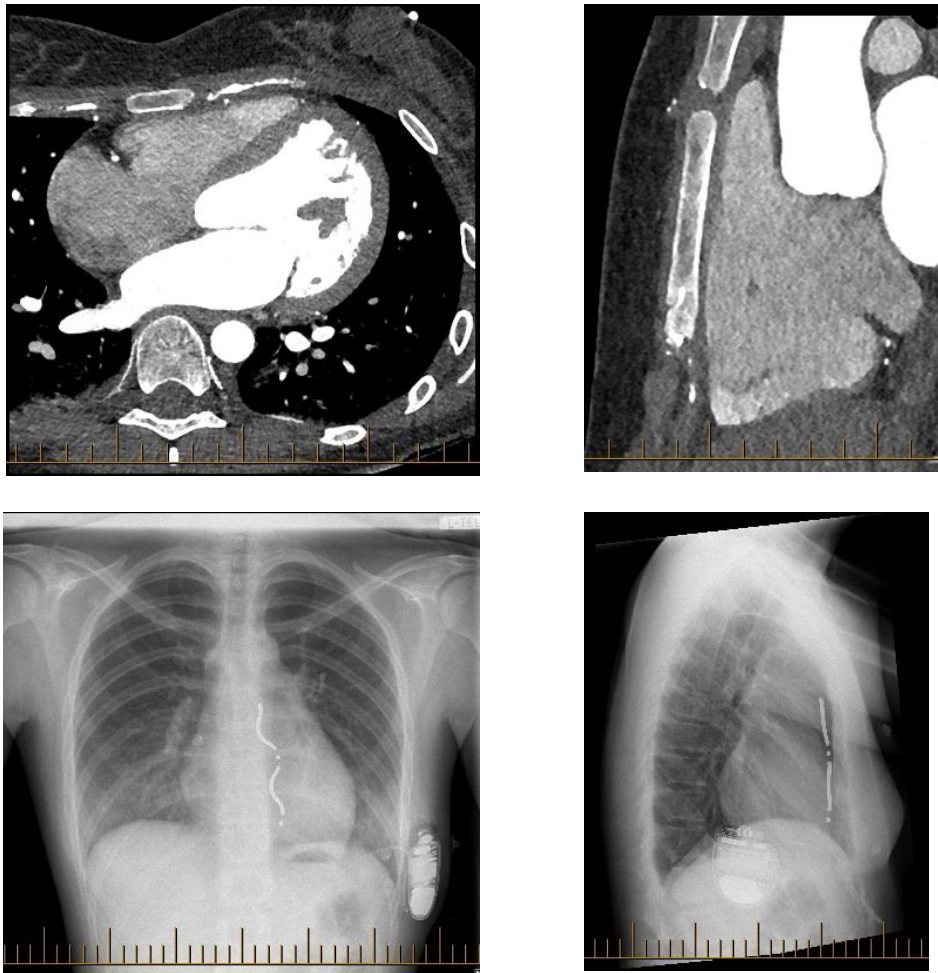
An 18 year old woman with a resuscitated VF arrest which was attributed to congenital long QT syndrome. Slices from her pre-procedure CT scan show close apposition of the sternum and the right ventricle and that the target area for the EV-ICD lead can often only be appreciated as a potential space. The PA and lateral chest radiographs show the final lead and device positions following successful implantation and defibrillation testing.
